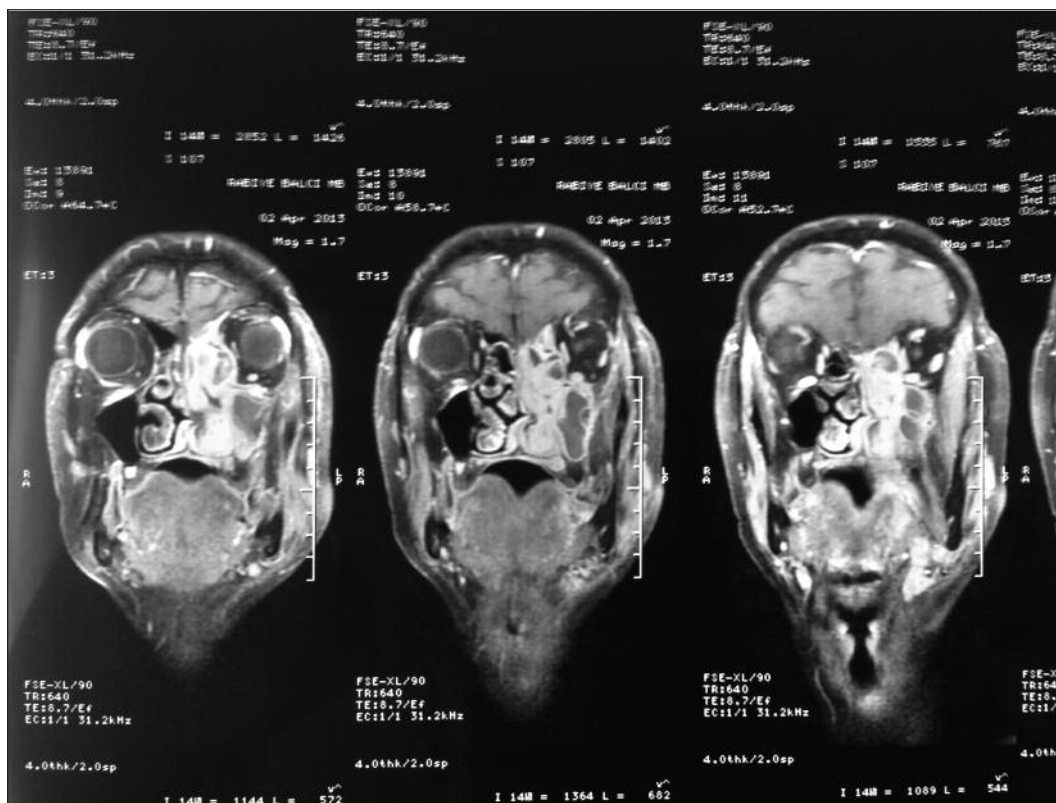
Coronal T1 Magnetic Resonance images of the patient.
